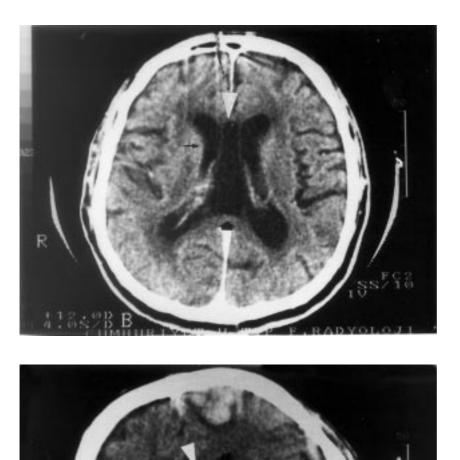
Axial brain computed tomographic scan showing CSP with CV. (white arrow-CSP, thick arrow-CV, arrow-lateral ventricle).
